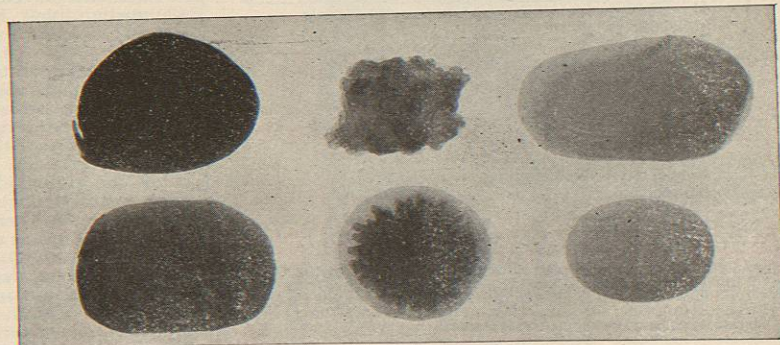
Radiograph of Calculi from the Pelvis of the Kidney. The two on the left are composed of uric acid and urates; those on the right of phosphates. The two calculi in the middle are composed of oxalate of calcium and uric acid, the upper one having an outside coating of urates. (From "The Roentgen Rays in Medicine and Surgery," by Francis K. Williams, M.D. Macmillan, 1901.)
